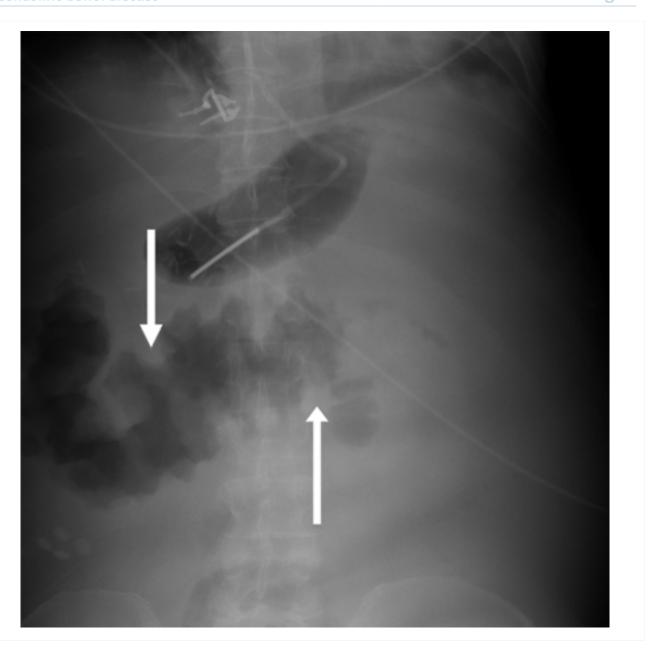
Plain abdominal x-ray: shows marked wall thickening of the transverse colon compatible with the finding of thumbprinting (white arrows)
